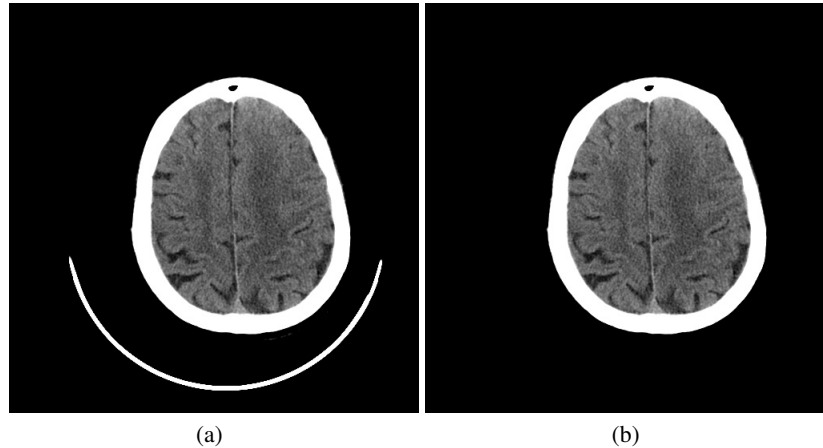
CT image filtering. (a) The original CT image with a fixation device. (b) Processed image with fixation device removed.
